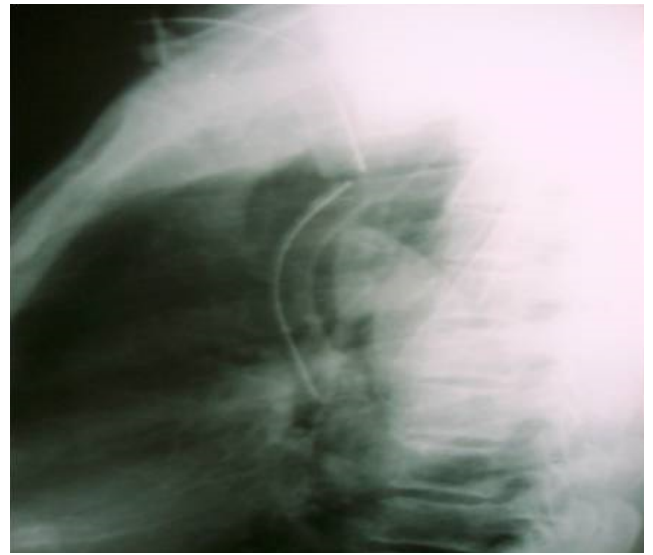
Xray lateral view of chest showing broken tracheostomy tube
